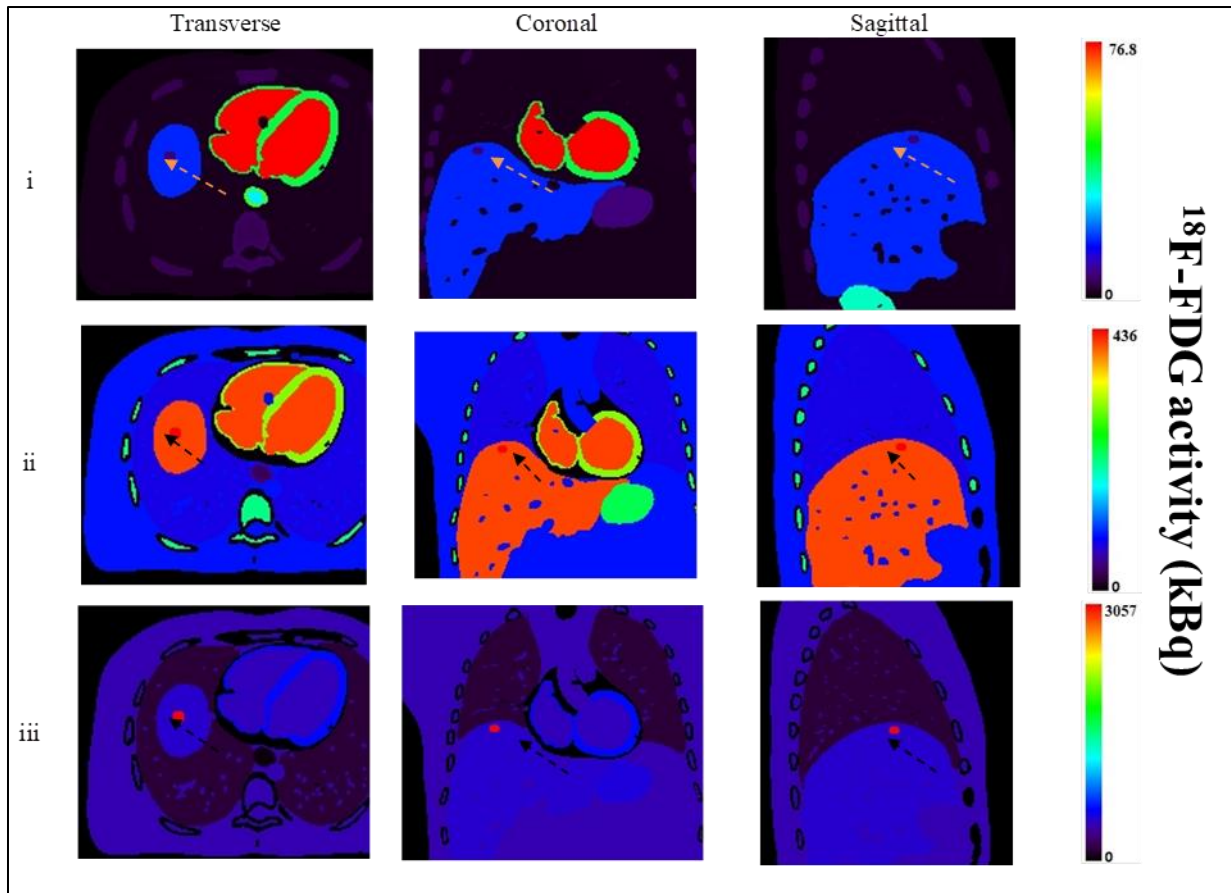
Transverse, coronal and sagittal images of ^{18}F -FDG activity maps taken at 3 different time points corresponding to : i = frame 1, ii = frame 17 and iii = frame 28. The arrow shows the lesion inserted in the liver.
